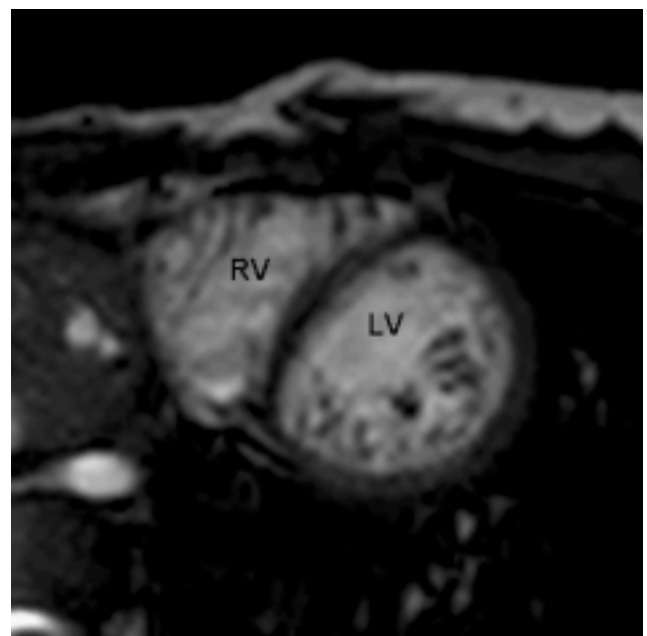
End-diastolic steady state free precession cine magnetic resonance images in short axis view at the apical level showing prominent trabeculations and a thin compacted layer.
